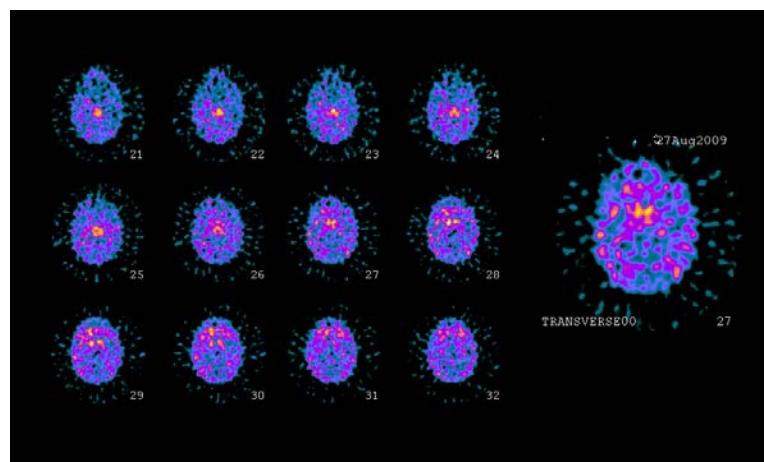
^{123}I -FP-CIT SPECT interpreted as severe presynaptic dopaminergic deficit in patient initially diagnosed with atypical parkinsonism (clinical stage 4.0 H&Y)
